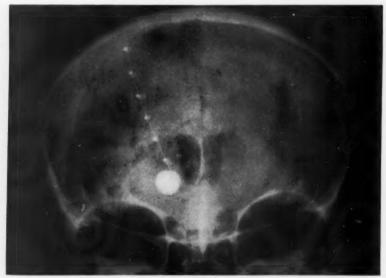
Roentgenogram demonstrating balloon cannula in place in the thalamus, with distention of the balloon within the thalamus by 0.5 c.c. of Hypaque. Distention of this balloon in the basal ganglia provides a clinical-physiologic test. When the balloon is distended in the proper locus in a conscious, coöperative patient, tremor and rigidity are immediately relieved in the contralateral extremities.
